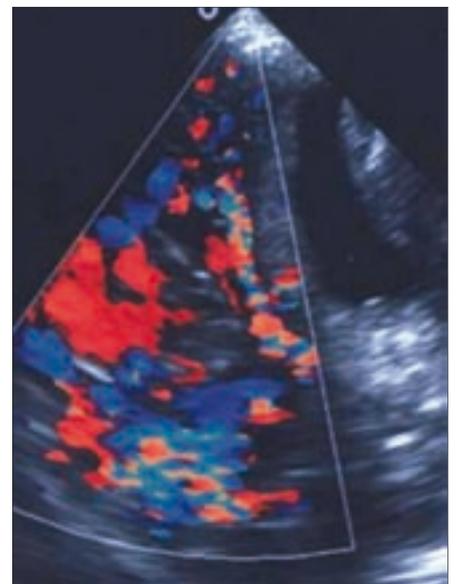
Color Doppler imaging shows multiple varicose pelvic veins in the right parauterine space that show continuity with the varicose veins located in the right inguinal canal.
